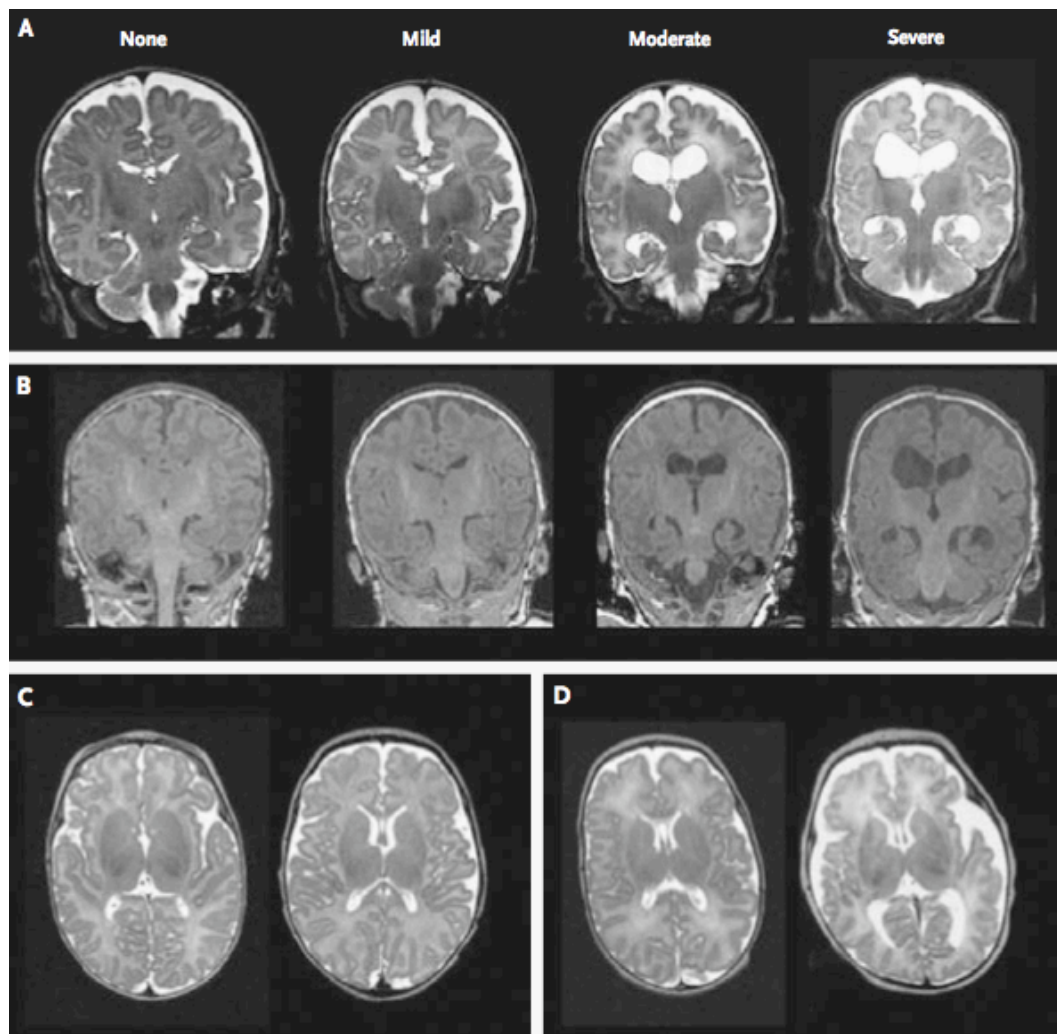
Representative MRI scans showing the increasing severity of white and grey matter injury of preterm infants included in the study (Woodward et al. 2006)
